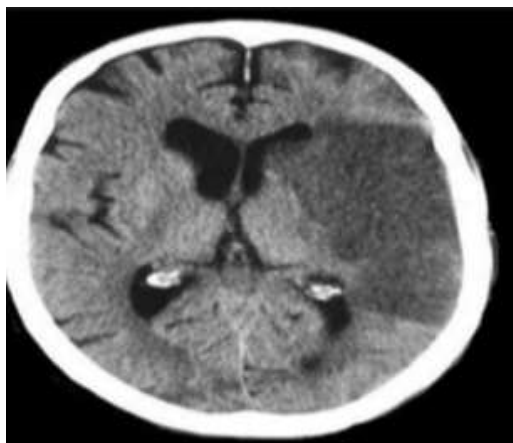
A 71 year old male patient known with DM, Dyslipidemia, over weight and significant (52%) left internal carotid artery stenosis, with postoperative right sided hemiplegia and right gaze palsy, CT brain showed left middle cerebral artery territory infarction.
